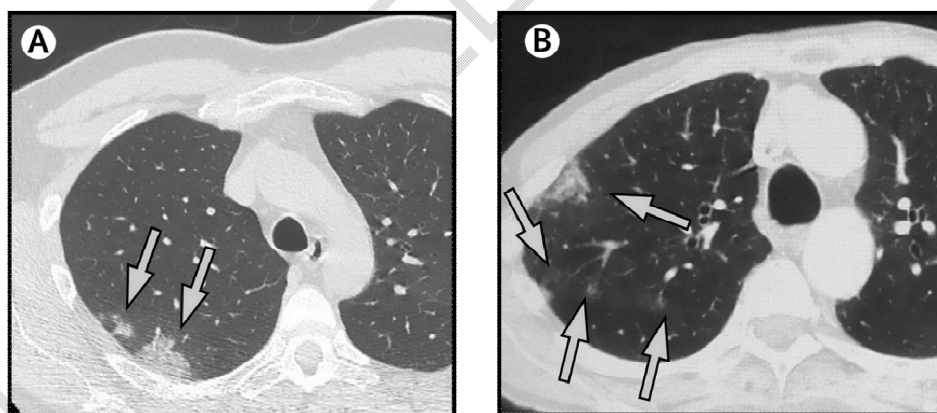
CT scans of pneumonia due to COVID-19 and immune checkpoint inhibitor therapy (A) Axial lung image (without intravenous contrast) of a 49-year-old man with COVID-19, showing two sub-solid areas in the upper right lobe (arrows). (B) Axial lung image (without intravenous contrast) of an immune checkpoint inhibitor-treated 76-year-old man with metastatic melanoma, showing a sub-solid area and ground-glass opacities with a rounded morphology in the upper right lobe (arrows). COVID-19=coronavirus disease 2019.
